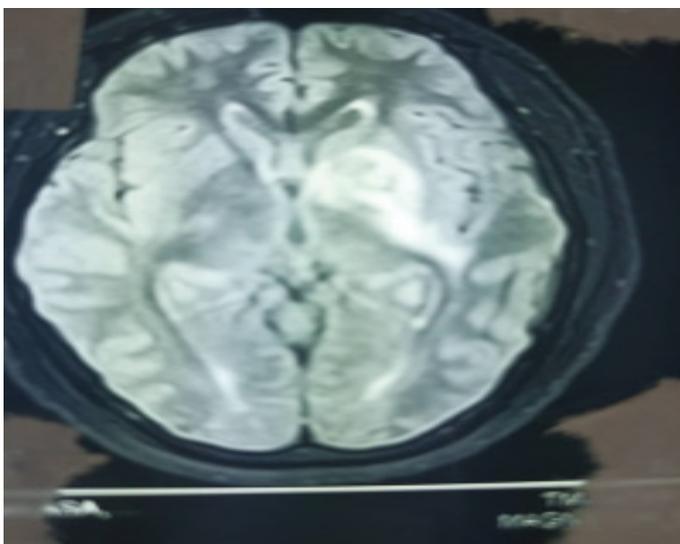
Brain MRI showing significant radiological improvement i.e., reduced size of the lesion.
